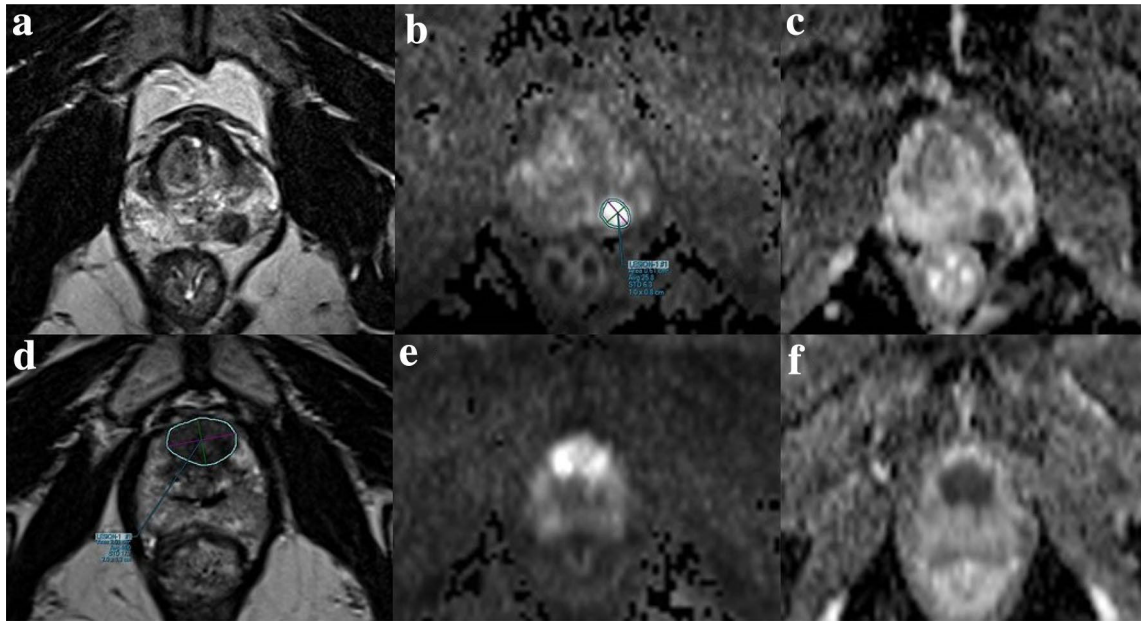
Prostate cancer in peripheral zone (PZ) in a T2-weighted MR image; b diffusion-weighted image (main sequence for lesion scoring and size measurement (1 cm) based on PI-RADSv2 criteria for PZ); c apparent diffusion coefficient (ADC) map; and in transition zone (TZ) in d T2-weighted MR image (main sequence for lesion scoring and size measurement (2 cm) based on PI-RADSv2 criteria for TZ); e diffusion-weighted image; f apparent diffusion coefficient (ADC) map
